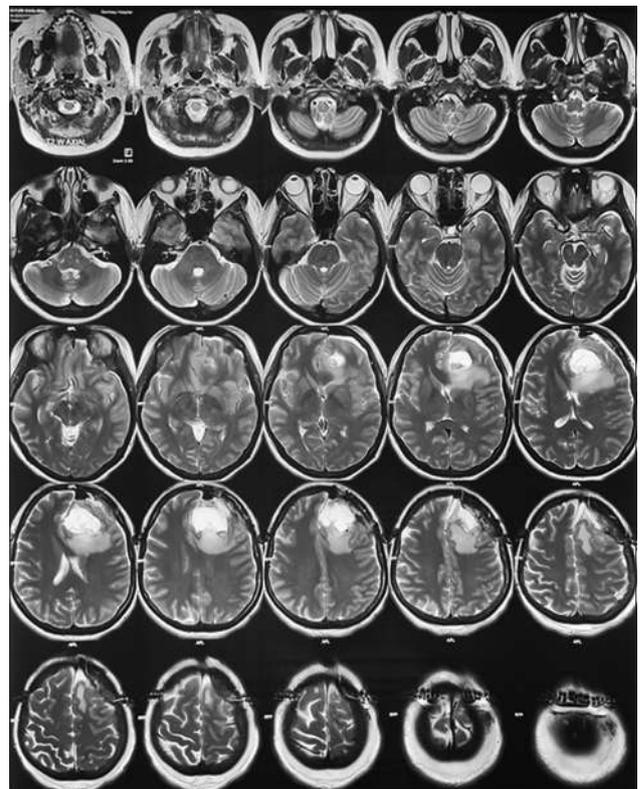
Transverse section magnetic resonance imaging shows meningioma
